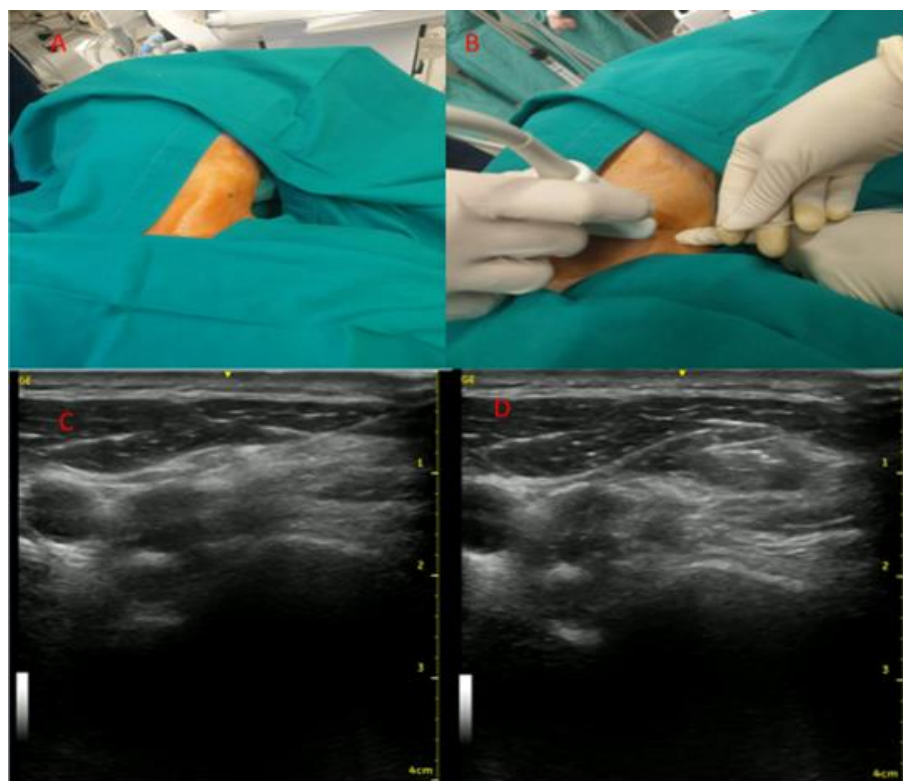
Technic of ultrasound guided superficial cervical plexus block
